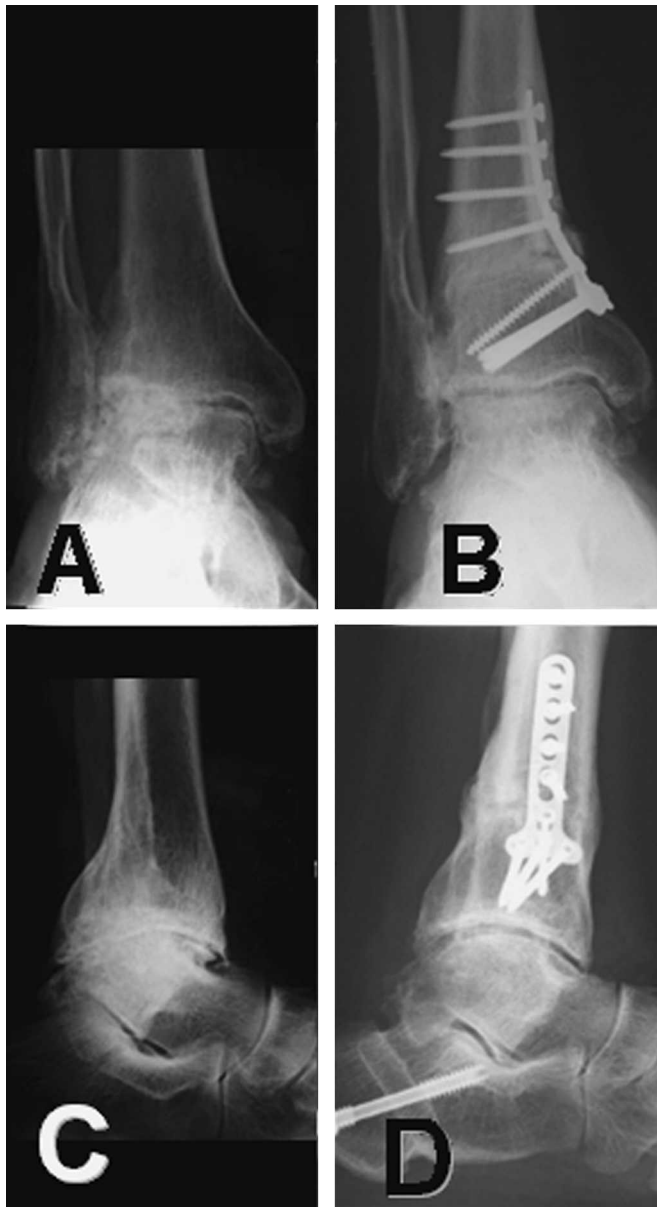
(A, C) Radiographs show the ankle of a 65-year-old man 16 years after ankle fracture. After failed nonoperative management, he refused ankle fusion several times and referred himself to undergo TAR. On weightbearing films, the joint degeneration appeared limited to the lateral compartment. Based on the patient's demands to continue running sports, realignment surgery was decided. A medial closing wedge tibial osteotomy and a medial sliding osteotomy of the calcaneus were performed. (B, D) Three years later, his joint line was still preserved; the collapsed part of ankle OA was stretched out to a parallel tibiotalar joint space on the frontal view. The patient was satisfied; he has no pain during activities of everyday living. At last followup, he still was participating in running sports with only mild symptoms after exercise.
